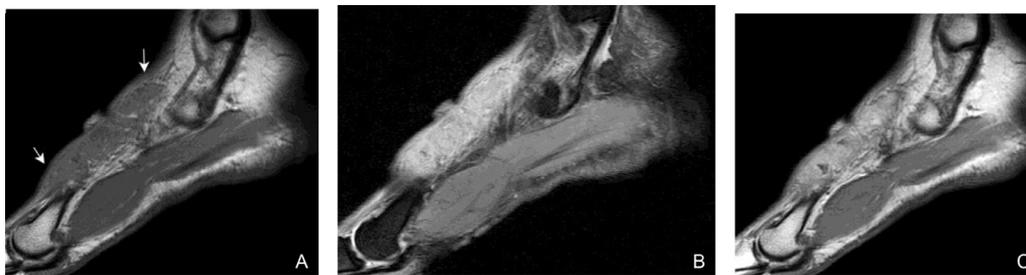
Acral myxoinflammatory fibroblastic sarcoma. (A) Sagittal T1WI shows an infiltrative mass along the dorsum of the foot that is iso intense to the muscle (white arrows). (B) On sagittal fat saturated T2WI, the mass is hyperintense. (C) Sagittal postcontrast T1WI shows diffuse homogeneous enhancement. T1WI, T1-weighted images; T2WI, T2-weighted images.
